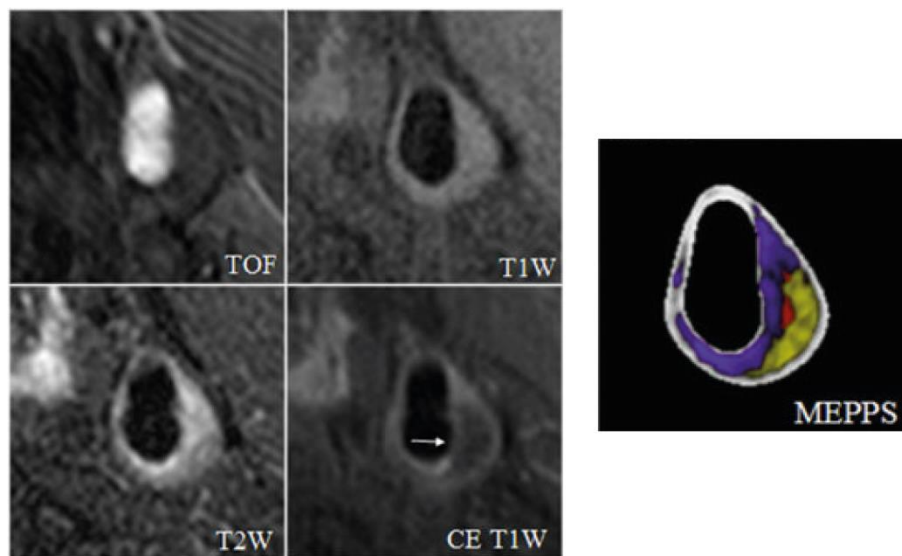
Structural characterization of atherosclerotic plaques by a combination of sequences. Time-of-flight (TOF), T_1 -weighted (T_1W), T_2 -weighted (T_2W), and contrast enhanced (by an injection of Gadolinium) T_1 -weighted (CE- T_1W) MR images are combined to produce the automated Morphology Enhanced Probability maPS (MEPPS). Loose matrix is shown in purple, lipid-rich necrotic core in yellow, and intraplaque hemorrhage in red on the MEPPS image. From Chu et al., 2009, JACC. Cardiovascular imaging.
